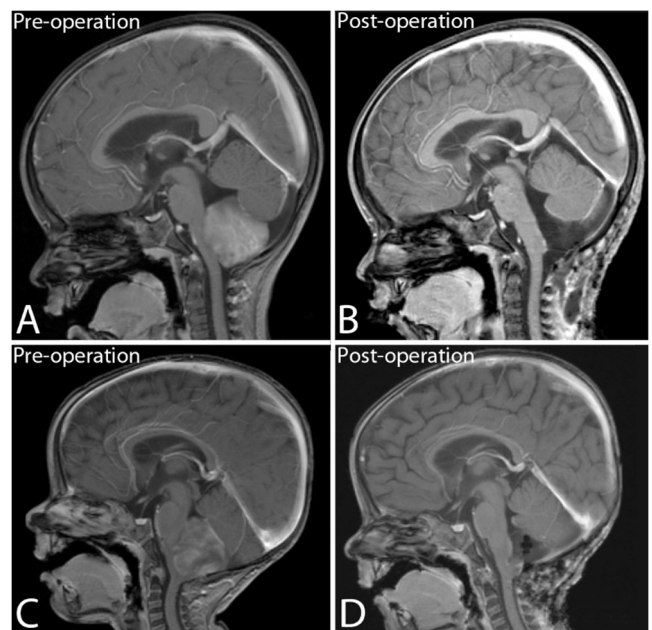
Pre- and post-operative head sagittal injected T₁-weighted MRI sequences in cases 1 and 2 with dorsally exophytic bulbar tumors. (A) A sequence in case 1 showing the caudo-rostral extent of the tumor. (B) An early post-operative sequence in case 1 showing a very small enhancing tumor residue. (C) A sequence in case 2 showing a very similar lesion as compared to (A). (D) An early post-operative sequence in case 2 showing a small tumor residue on the dorsal part of the bulba.
